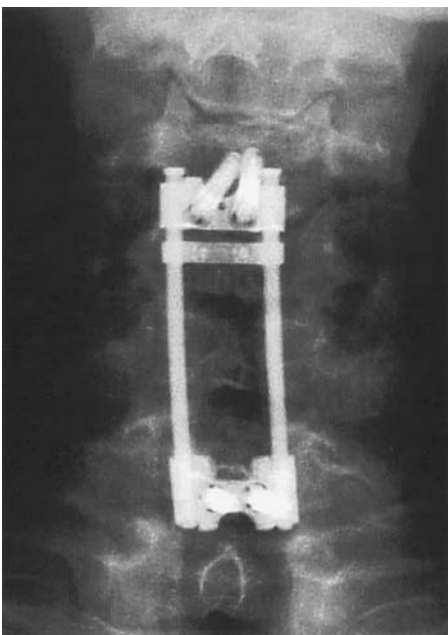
AP radiograph of first generation dynamic fixation with DOC rod system.
